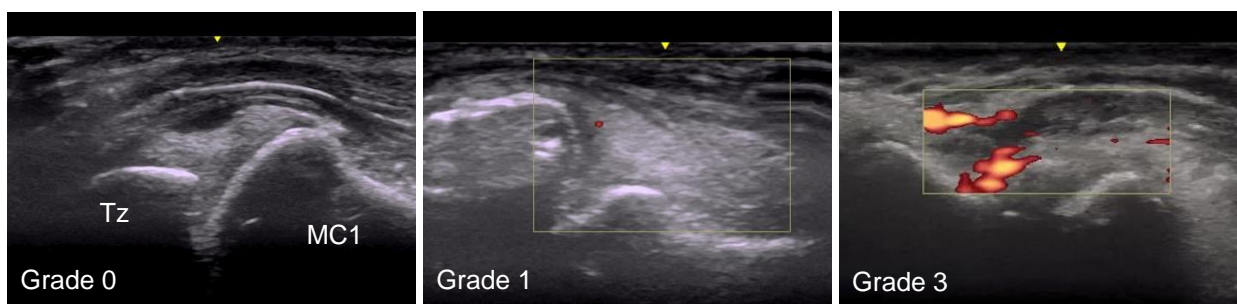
Ultrasound images of the thumb CMC joint with examples of synovitis grade (power Doppler and greyscale). Tz, trapezium; MC1, first metacarpal.
